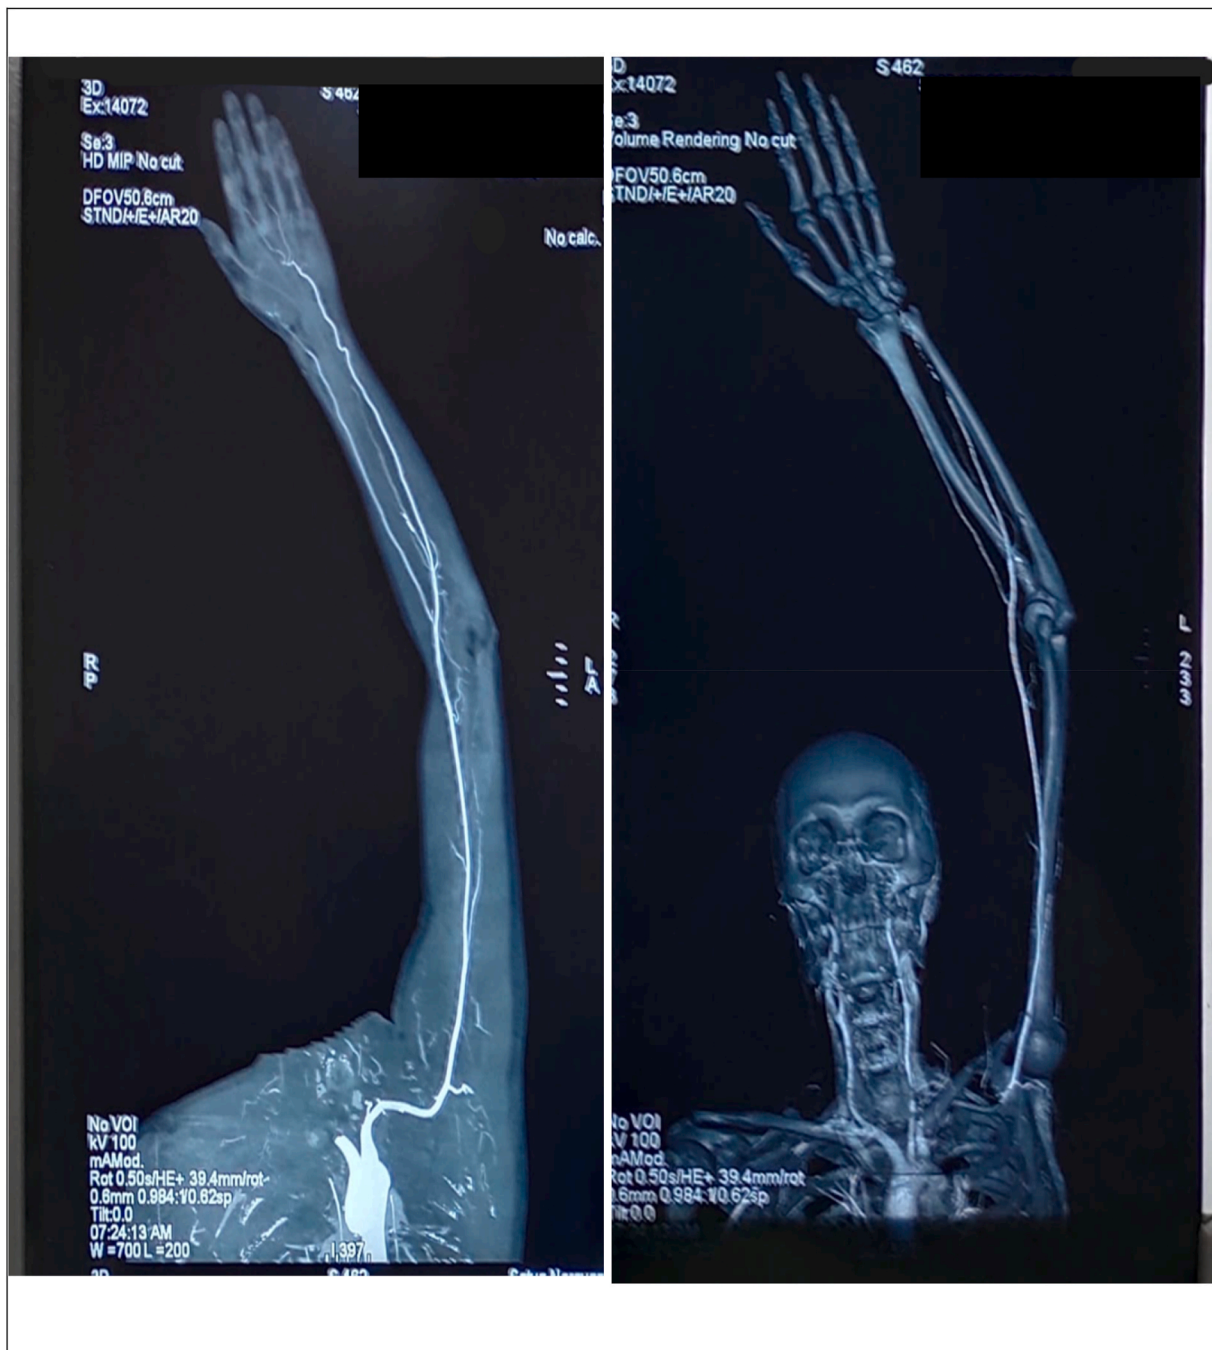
CT Angiography of left upper limb dated 06/09/22
